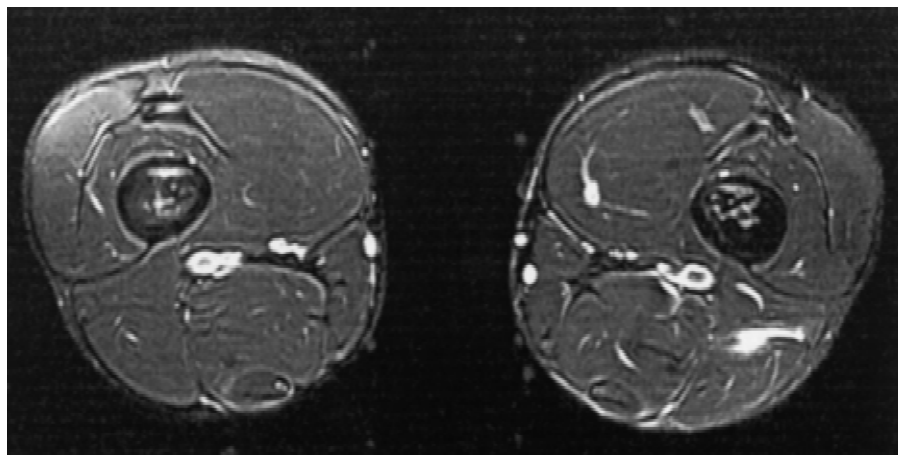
Day 4 axial fast spin echo T2-weighted magnetic resonance imaging scan showing grade 1 (10% cross-sectional area) strain of left biceps femoris muscle, long head (on right side of figure).
